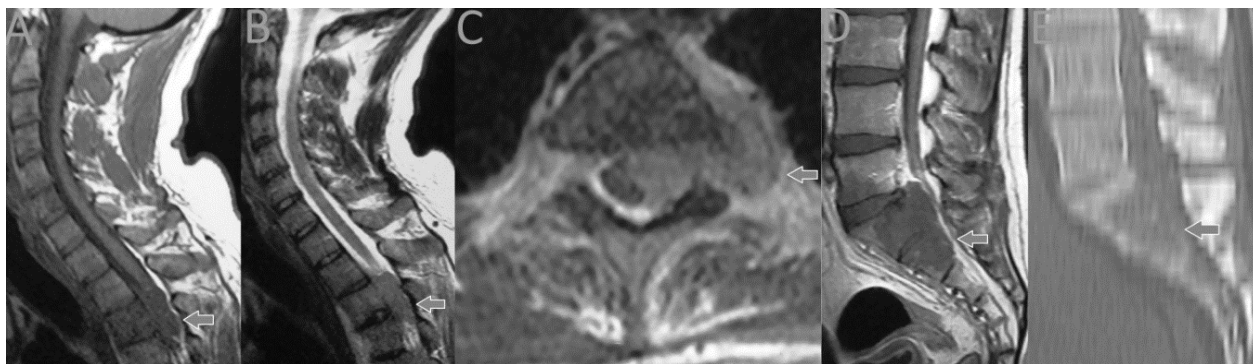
Patient 2 imaging. A: sagittal cervical T1 WI MRI; B: sagittal cervical T2 WI MRI; C: axial cervical T2 WI MRI; D: sagittal lumbosacral T2 WI MRI; E: sagittal lumbosacral bone window CT.
